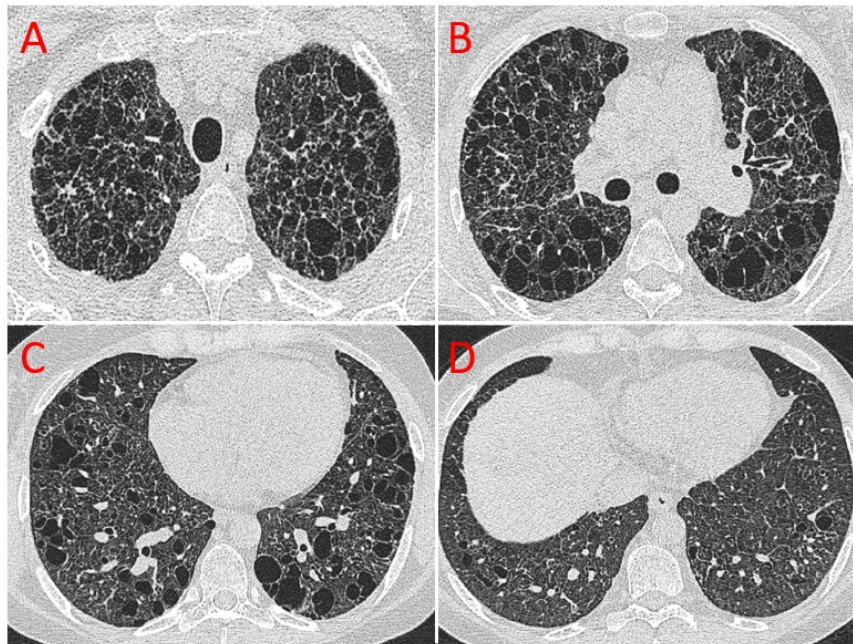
High resolution CT dicom's from a patient with Langerhans cell histiocytosis from the ILD-PH cohort.
